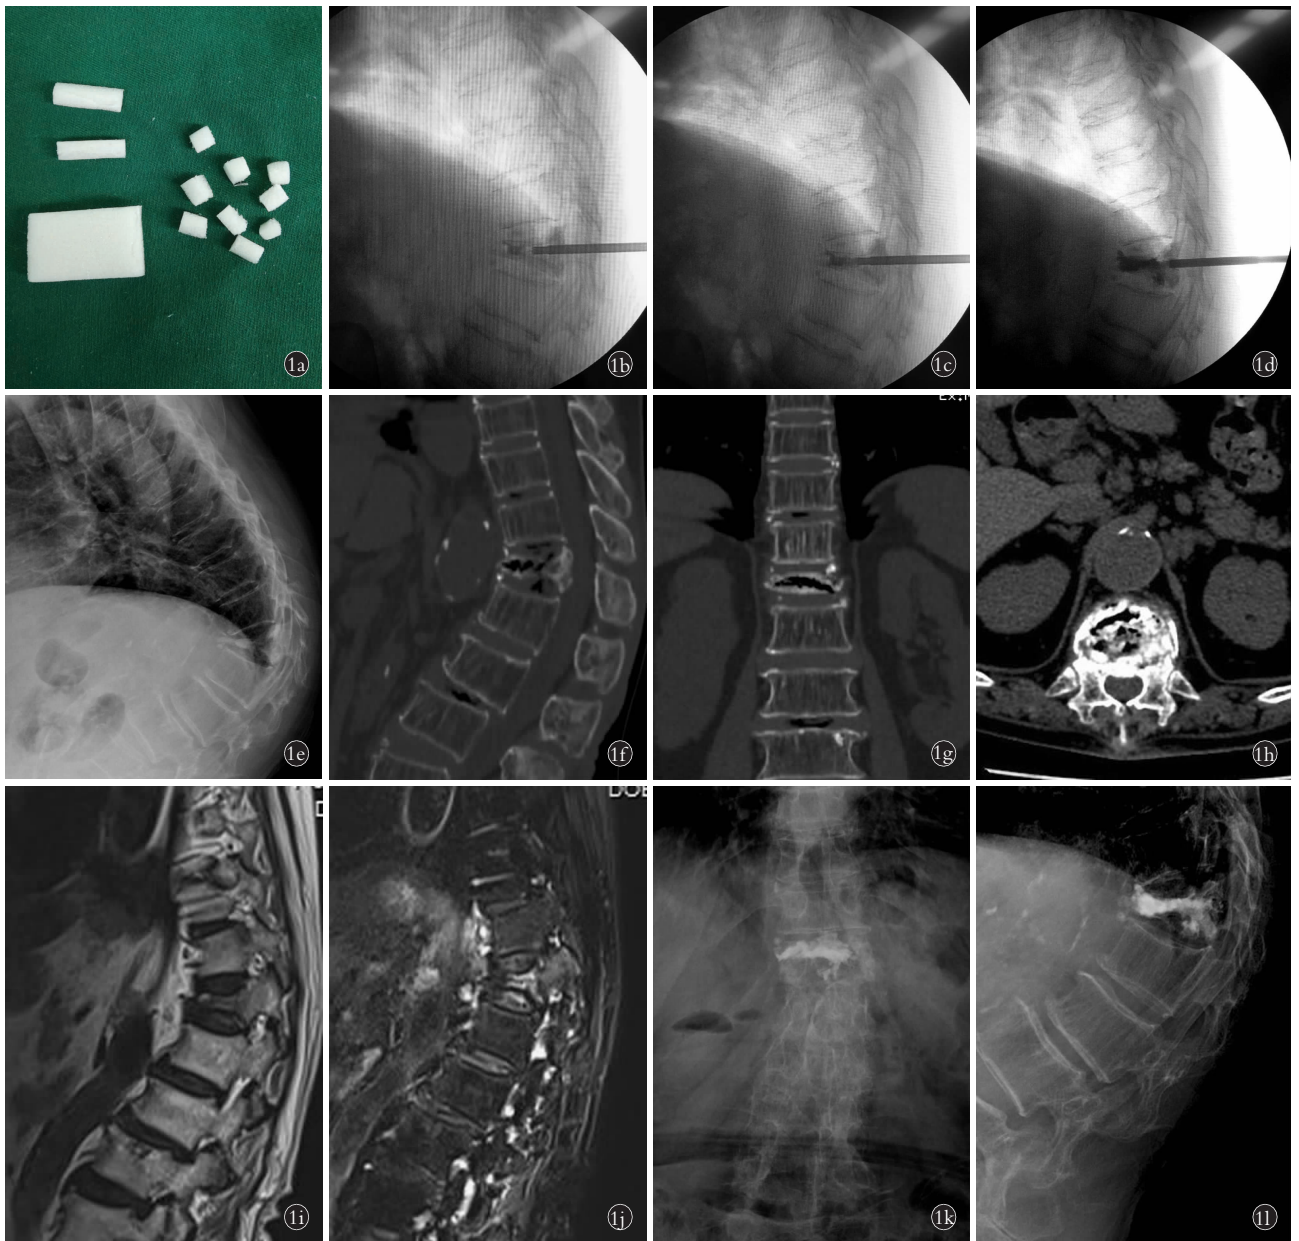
患者,女,75岁,T₁₂椎体 Kümmell 病 1a.制作的明胶海绵颗粒 1b.骨水泥前方被明胶海绵颗粒阻挡 1c,1d.骨水泥弥散向前推挤明胶海绵,但未渗漏出椎体前方皮质缺损处,少量向上方椎间隙渗漏 1e.X 线片显示 T₁₂椎体压缩性骨折,前柱压缩严重 1f,1g,1h.T₁₂椎体内见不规则的真空裂隙,裂隙上下边缘硬化,椎体前壁皮质破损,椎体前方紧贴主动脉 1i,1j.T₁₂椎体 MRI 显示 T1 低信号,T2 高信号,见双线征 1k,1l.T₁₂椎体 PKP 治疗后第 3 天 X 线片,前方未见骨水泥渗漏,上方椎间隙少量骨水泥渗漏
